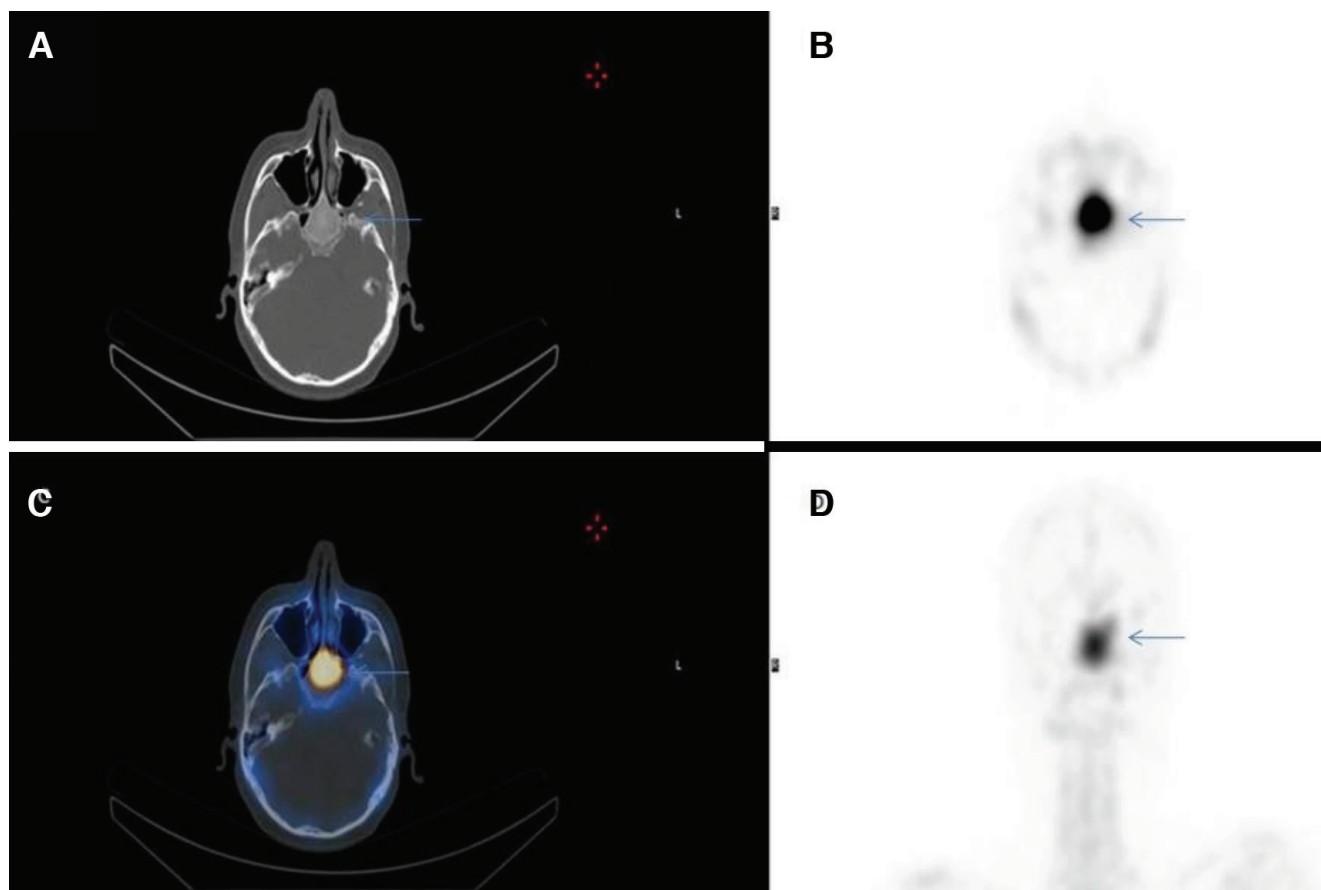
Computerized tomography (CT) (A), single-photon emission CT (SPECT) (B), fusion (C), maximum intensity projection (D) images on SPECT/CT hybrid imaging of Tc-99m-MDP bone scintigraphy that localize and spot the uptake on planar images in the sphenoid bone (arrows).
